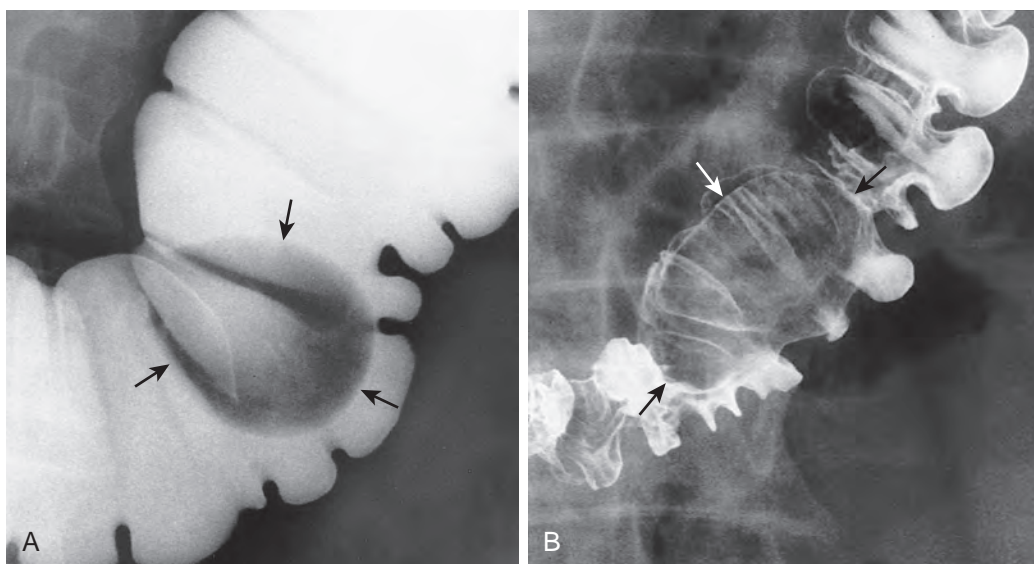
Pliability. A. Lipoma of the colon. A pear-shaped, smooth-surfaced filling defect (arrows) is seen in the barium column. B. A postevacuation radiograph shows that the polypoid mass has elongated (arrows) to conform to the collapsed lumen. These are classic findings of a colonic lipoma.
